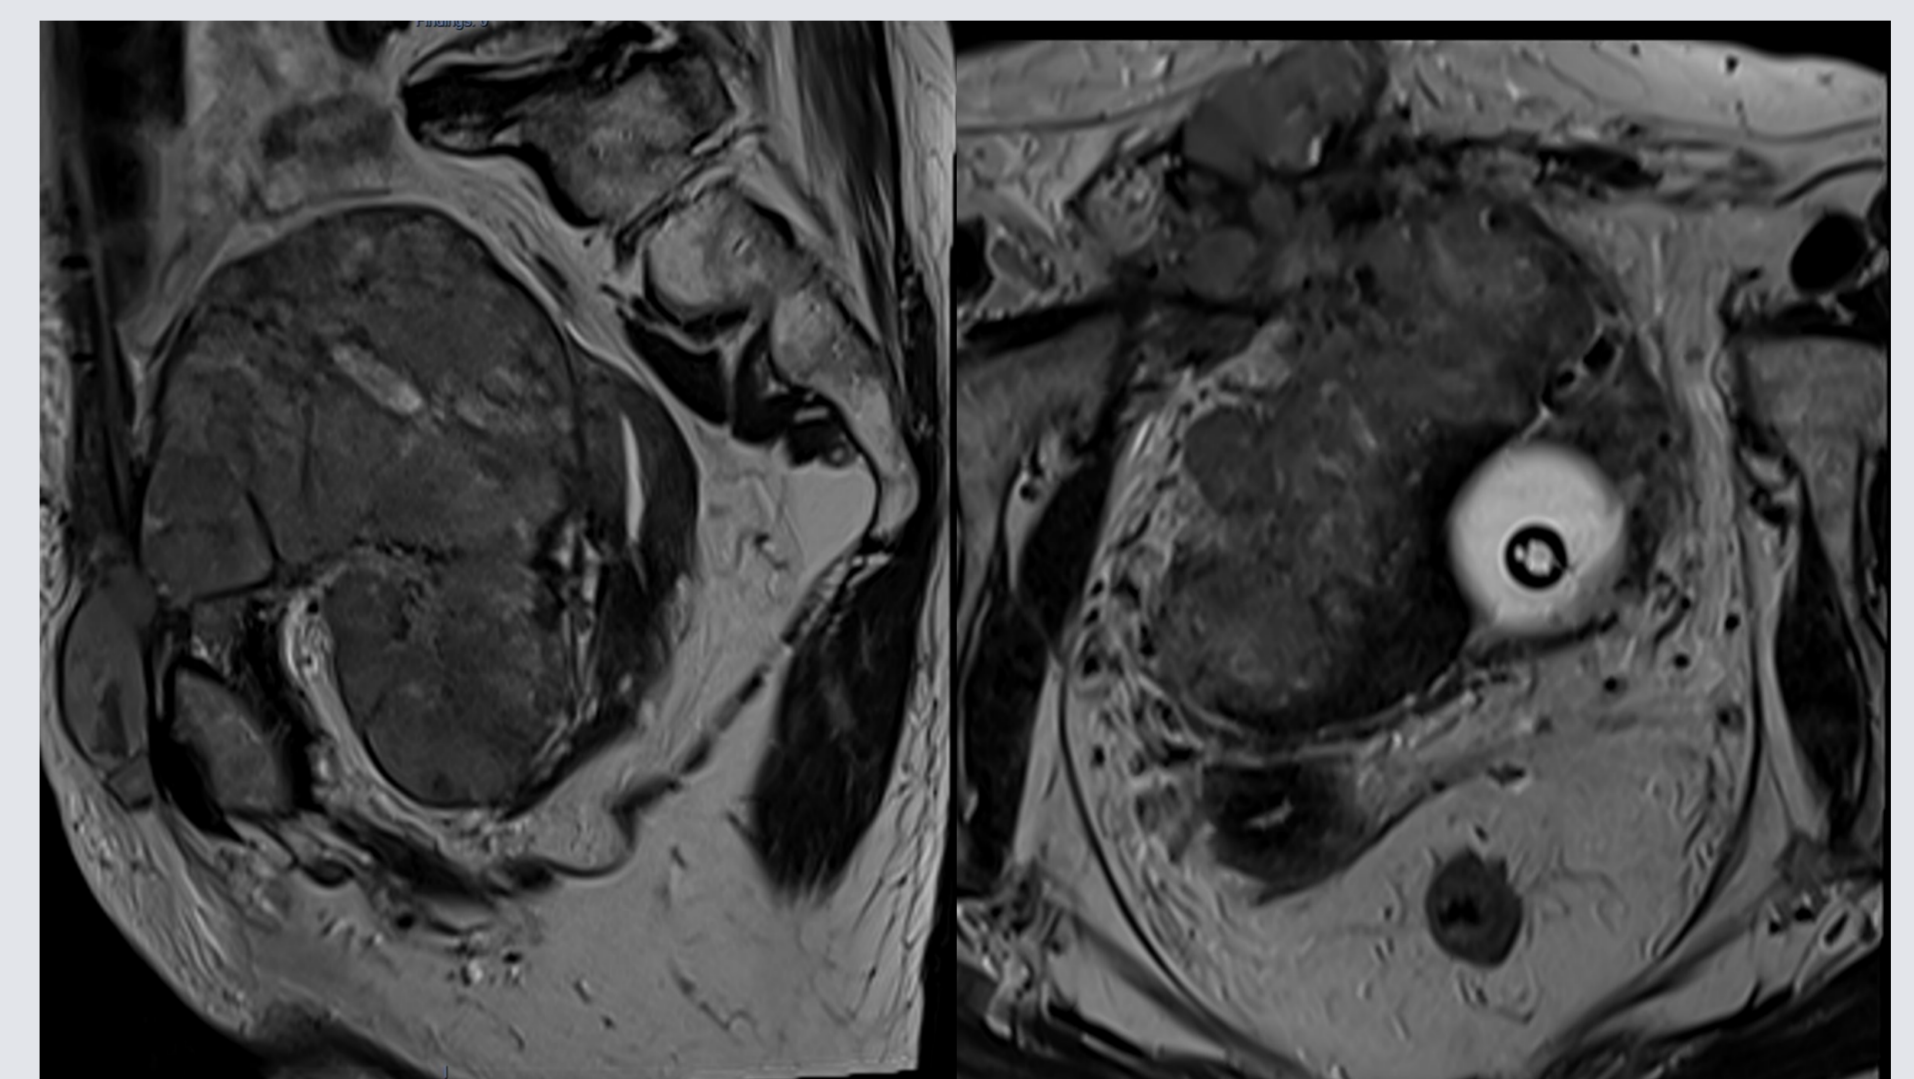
This lesion was staged as pT1 on TURBT but MRI shows extensive T4b disease.
